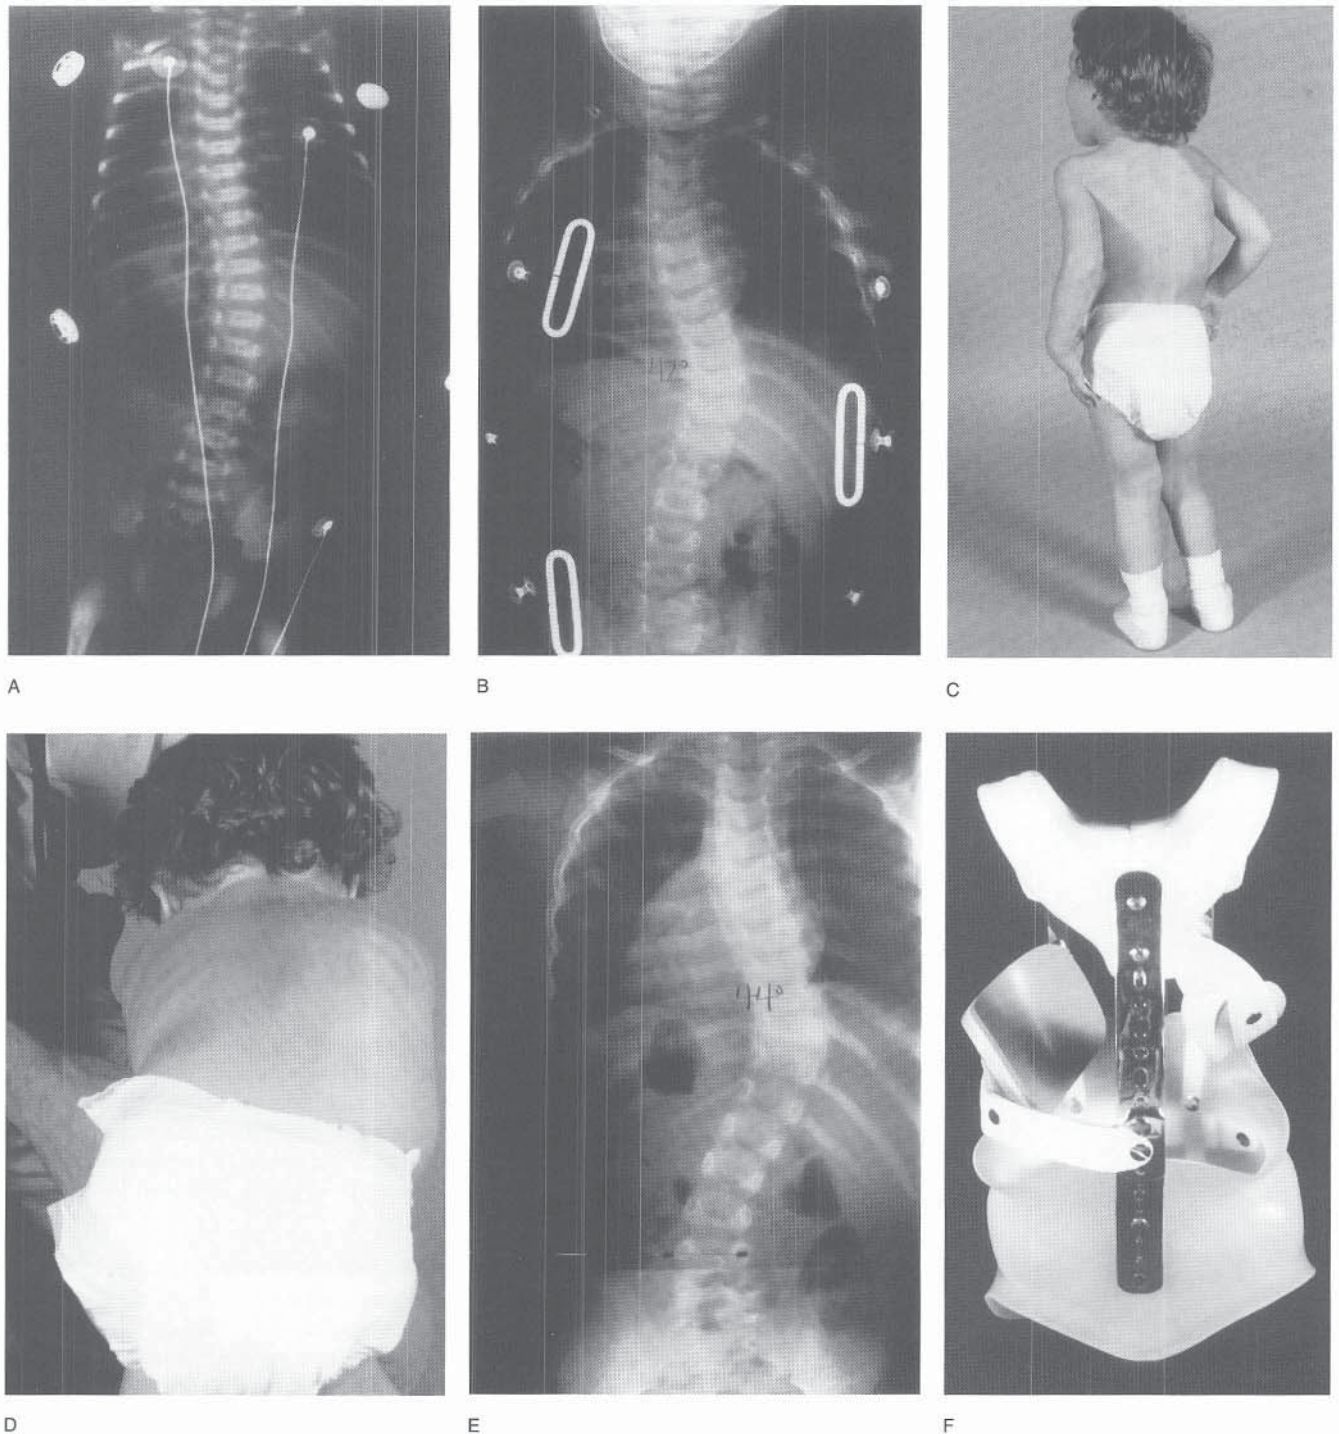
Treatment of infantile scoliosis. Radiograph of the spine of a newborn infant demonstrated a mild right lower thoracic idiopathic scoliosis (A). On presentation at age 13 months, the rib-vertebral angle measured 27 degrees (phase 1). At age 16 months, the curve measured 42 degrees with the child in a brace (B). At age 3 years 8 months, scoliosis was clearly evident clinically (C, D) and measured 44 degrees radiographically (E).
